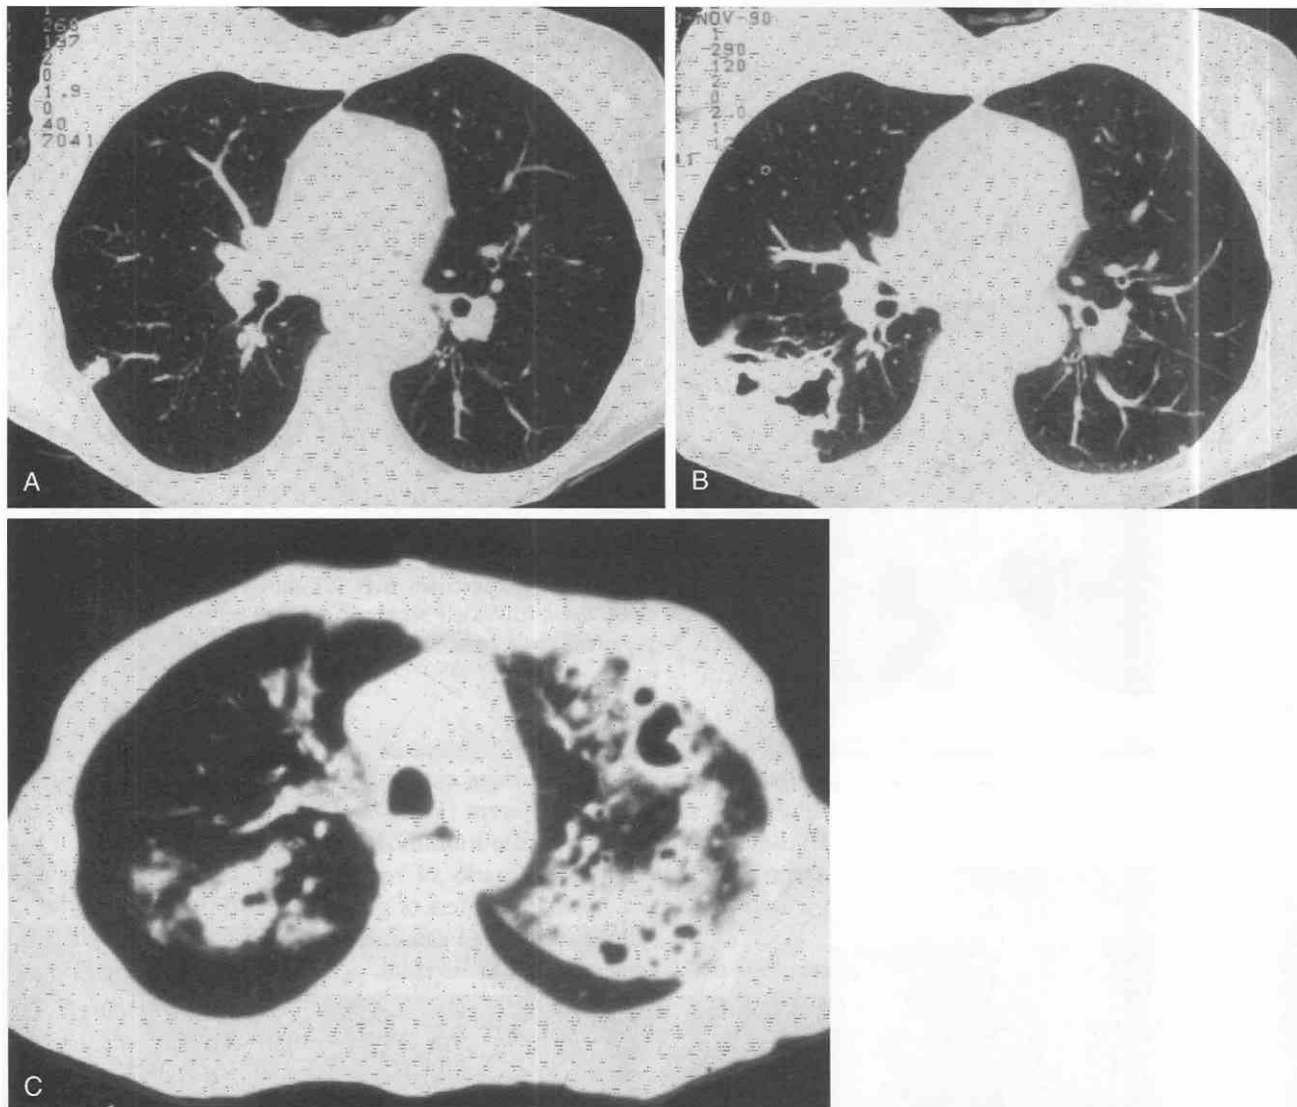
Nocardiosis in a patient with acquired immunodeficiency syndrome (AIDS). A. Initial CT scan on a patient with positive status for human immunodeficiency virus (HIV) infection shows a small inflammatory nodule in the right lower lobe. B. *Nocardia* infection has progressed to a large necrotic cavity. C. *Nocardia* infection in another patient with AIDS presented as a multilobar cavitory pneumonia. (C, From Kuhlman JE: AIDS-related diseases of the chest. In Kuhlman JE [ed]: CT of the Immunocompromised Host. New York, Churchill Livingstone, 1991.)
